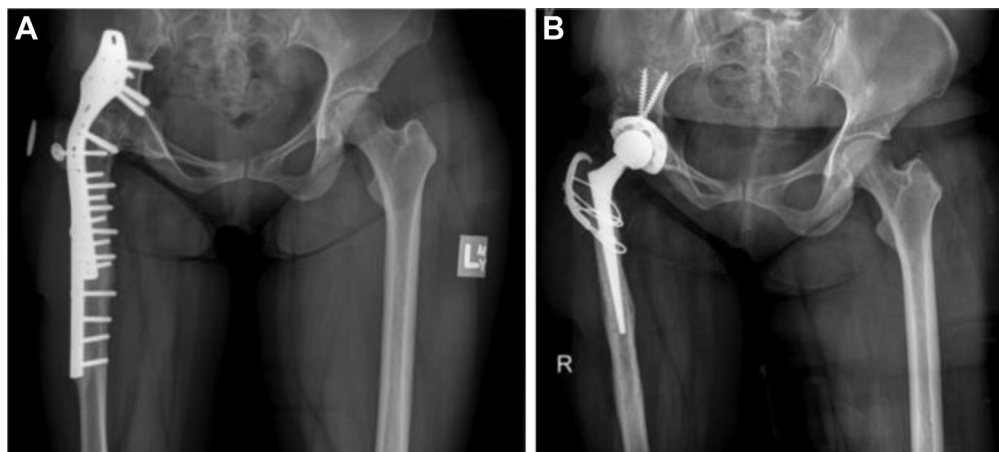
The case of a patient presenting with low back pain attributed to a previous successful right hip arthrodesis for the treatment of secondary coxarthrosis because of septic arthritis in childhood. A subsequent fracture was treated with open reduction and fixation: (A) preoperative radiograph demonstrating evidence of significant deformity of the proximal femur; (B) postoperative radiograph with evidence of integration of both femoral and acetabular components and union of the trochanteric osteotomy.
